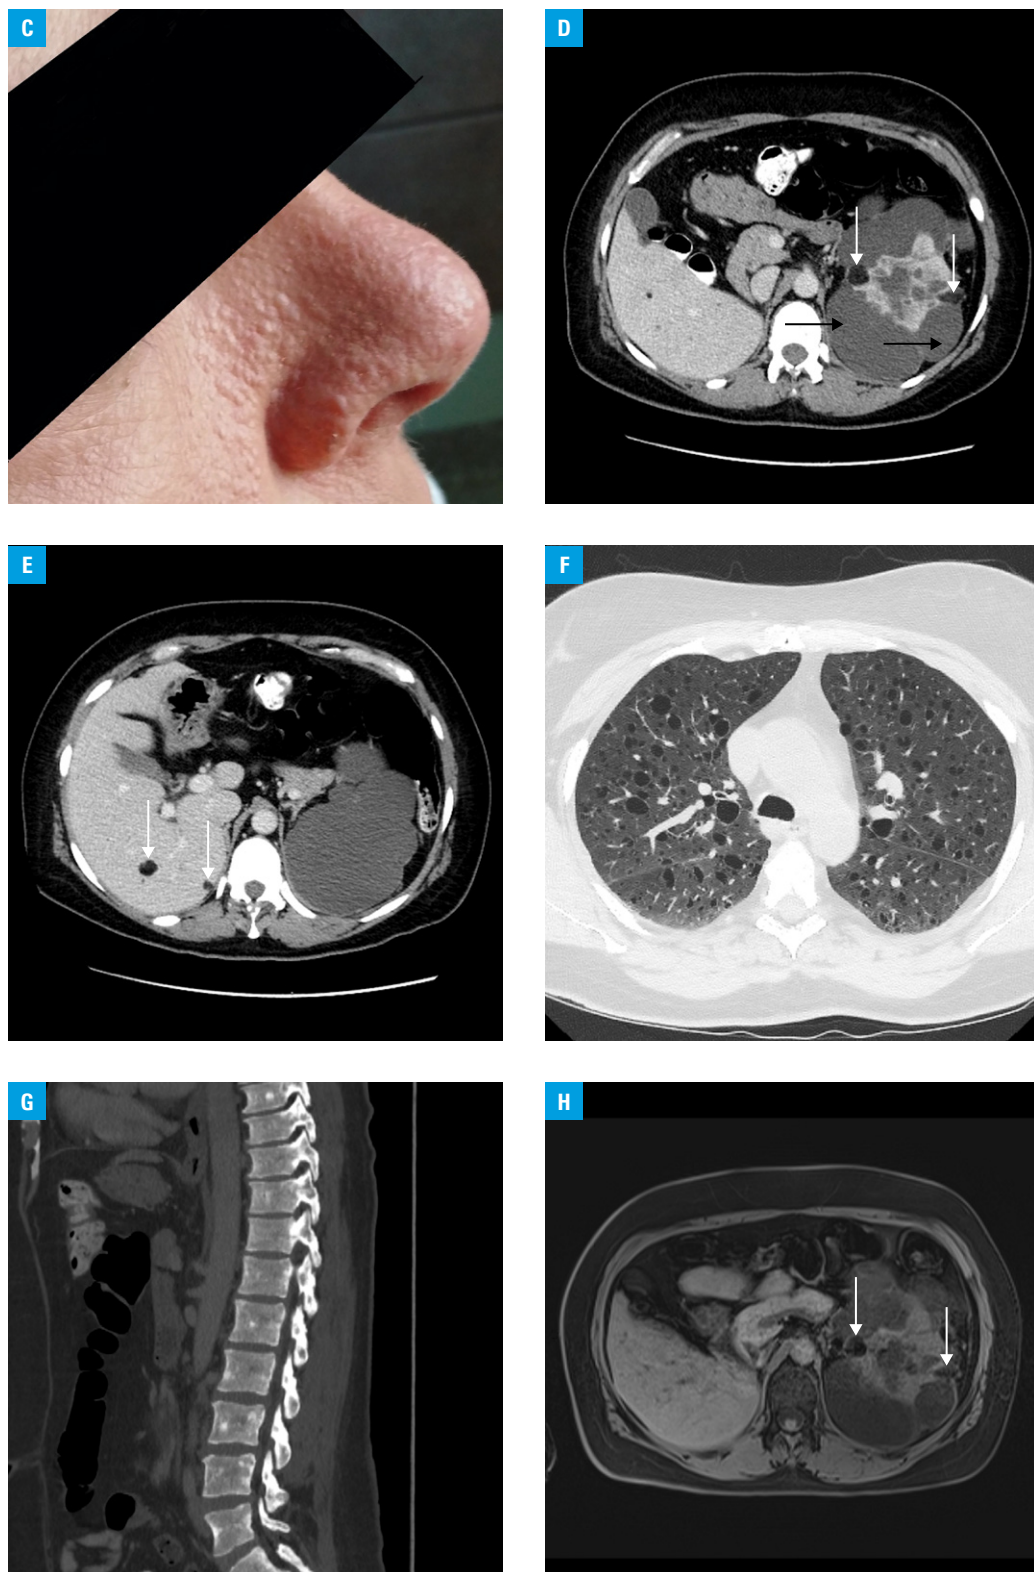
Imaging of an adult woman with tuberous sclerosis: C – shagreen patches around the nose; D – computed tomography of the abdomen, venous phase, showing the left kidney with numerous peripheral cysts (black arrows) and a few angiomyolipomas (white arrows); E – computed tomography of the abdomen, venous phase, showing liver angiomyolipomas (arrows); F – computed tomography of the chest showing lymphangioleiomyomatosis; G – computed tomography showing osteosclerotic foci in the spine; H – magnetic resonance of the abdomen, fat saturation sequence, showing angiomyolipomas of the kidney (arrows). The authors obtained informed consent from the patient.
